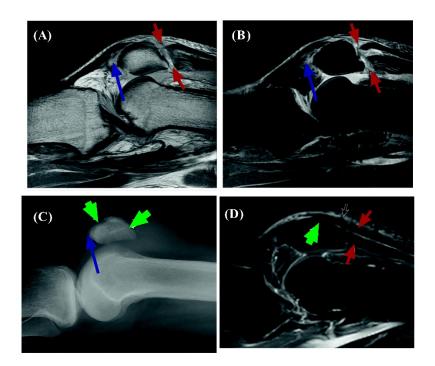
A case study of a 28-year-old male with a QT tear. Section A shows the medialweighted MR image without fat saturation and Section B with fat saturation at the osseotendinous junction (red arrows). The blue arrows show a partial tear occurring at the proximal patellar tendon. This patient was subjected to surgical treatment using a transpatellar bone tunnel tendon fixing technique (green arrows) within 1 month of follow-up (section C). Additionally, in section C, ossification occurs at the tear of the proximal patellar tendon (red arrows). In section D, the T1-axial fat-saturated MR images after 36 months of surgery reveal an intact QT (red arrows) a post-operative artifact (blue arrows), and ossified surgical tunnels (green arrows).
